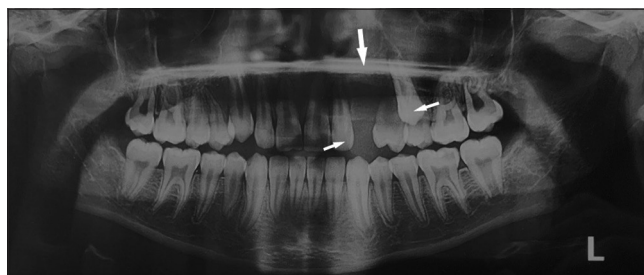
Panoramic radiograph revealing an ill-defined lesion extending from tooth #10 to the #12 region.
